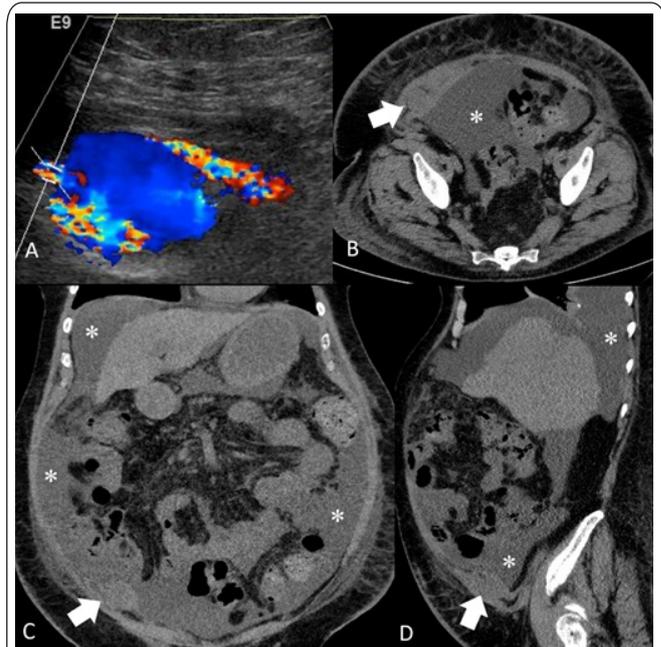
An ultrasound targeting the right lower quadrant of the abdomen was performed. This corresponds to the puncture site, where the abdominal paracentesis was performed the day earlier. A 23 x 20 x 35 mm pseudoaneurysm (arrows) was identified arising from the right inferior epigastric artery (Image A). Due to the patient's poor renal function, a non-contrast CT abdomen was subsequently performed which demonstrated large volume ascites (asterisks) and a rounded hematoma in the anterior abdominal wall, right inferior-lateral aspect, localized to the site of the pseudoaneurysm seen on the targeted ultrasound [Images B (axial), C (coronal), and D (sagittal) – arrows]. Successful thrombosis of the pseudoaneurysm was achieved following UGTI of 300 IU without immediate complications encountered.
